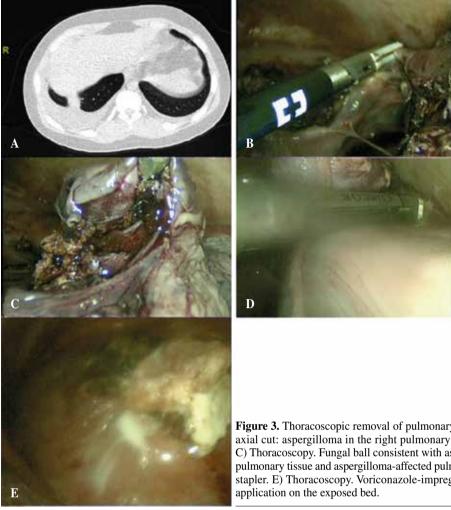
Thoracoscopic removal of pulmonary aspergilloma. A) Pulmonary CT-scan axial cut: aspergilloma in the right pulmonary base. B) Thoracoscopy. Adhesiolysis. C) Thoracoscopy. Fungal ball consistent with aspergilloma. D) Thoracoscopy. Healthy pulmonary tissue and aspergilloma-affected pulmonary tissue separation using an endostapler. E) Thoracoscopy. Voriconazole-impregnated hemostatic material (Tachosil®)
